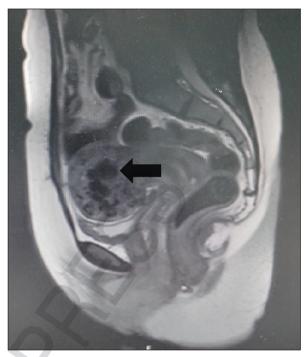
Sagittal plane of the pelvic magnetic resonance image shoved the uterus is voluminous, and lesions consistent with dilated vascular structures are observed within the parenchyma.
